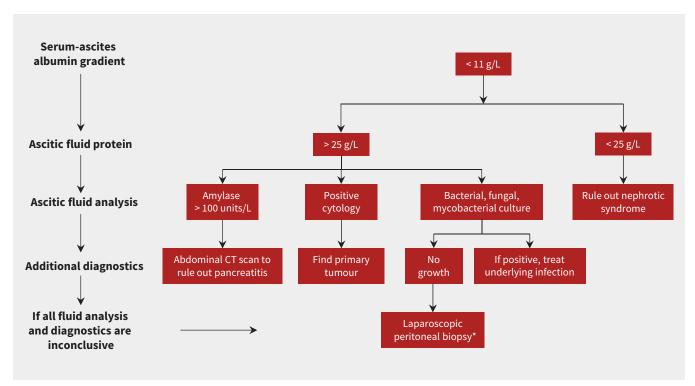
Suggested diagnostic approach to a patient with exudative ascites. Low ascitic fluid protein should direct practitioners to rule out nephrotic syndrome as a cause for exudative ascites. *Consideration of lymphangioscintigraphy can be done at this point to rule out lymphatic obstruction before invasive procedure. Note: CT = computed tomography.^{1,4,5,6}
